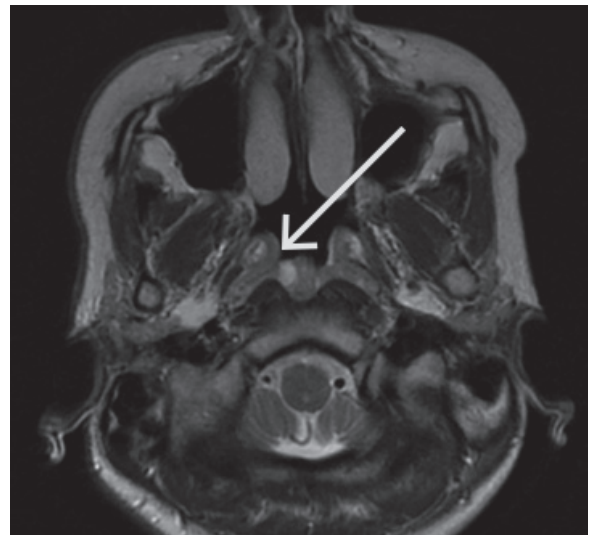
Axial MRI T2 image. Notice a small hyperintense and rounded lesion in intimate relation with the medial aspect of the fossa of Rosenmüller. This was interpreted as a pharyngeal retention cyst.
